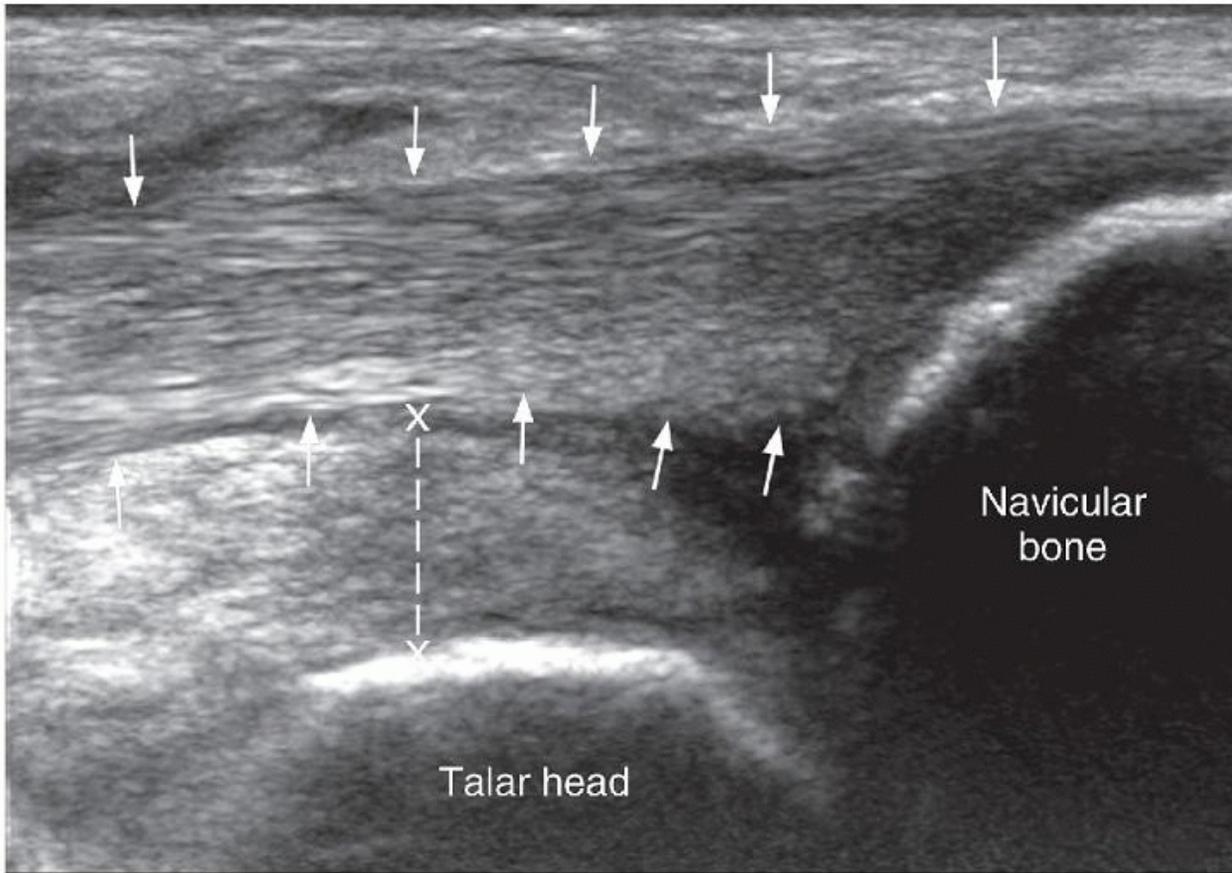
Longitudinal ultrasound medial aspect of midfoot showing mild insertional tendinosis of posterior tibialis tendon with thickening (arrows). There is also moderate thickening (dotted line) of the superomedial component calcaneonavicular (or spring) ligament deep to the posterior tibialis tendon. The ligament is 6.4-mm thick, while the normal ligament thickness should be <4.0 mm.
